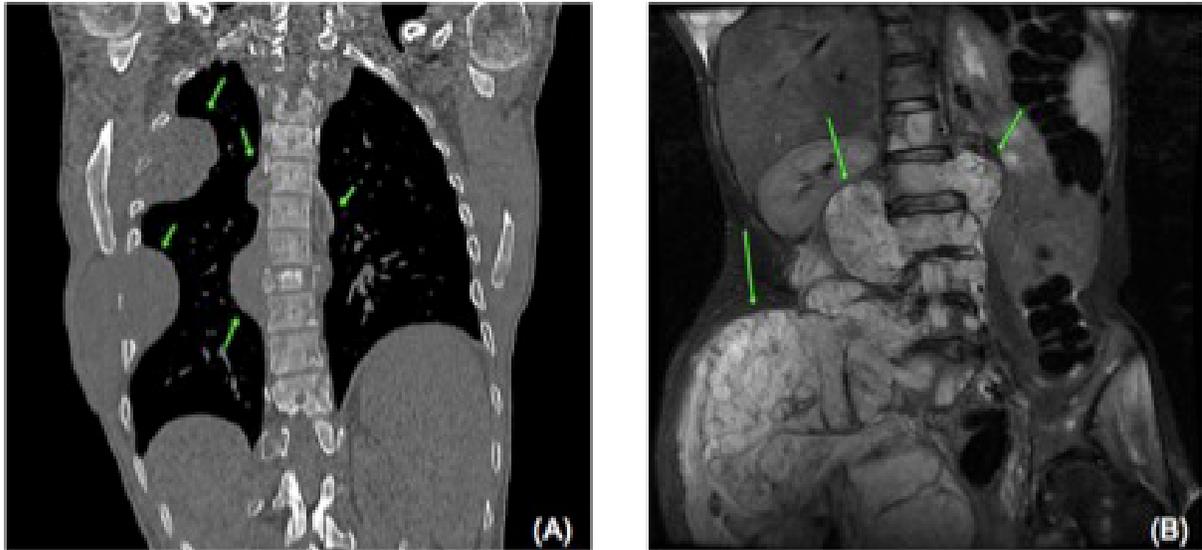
Patient metastases in the vertebral column, soft tissues of the chest wall, liver, and pleural space. (A): Computed tomography scan of the chest. (B): Magnetic resonance imaging.
